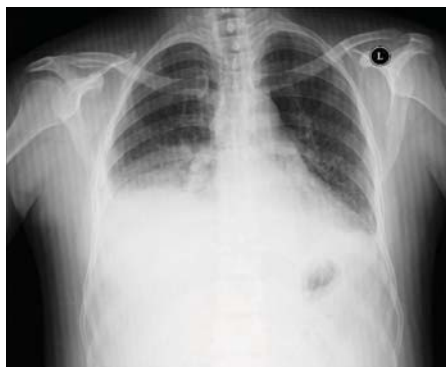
Pleural effusion in posteroanterior (PA) chest X-ray.
